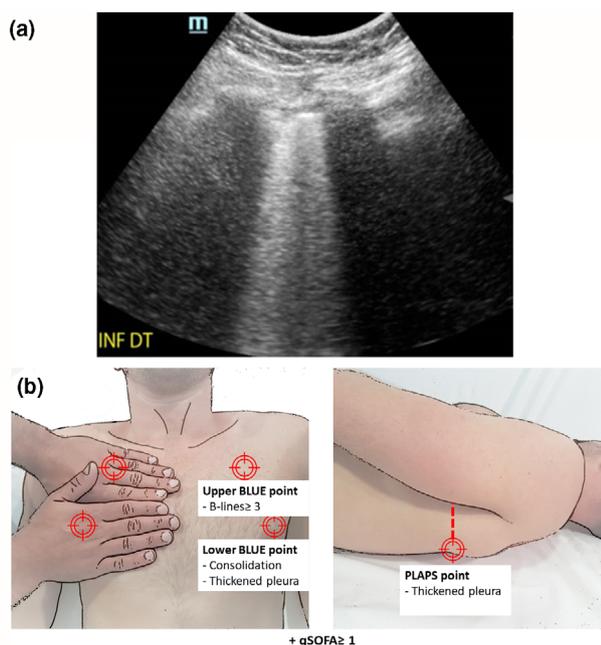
(a) Lower anterior chest subpleural consolidation associated with thickened pleura. (b) The 'bed-side lung ultrasound in emergency' (BLUE) protocol interrogates three points in each hemithorax. The two anterior sites are under one (upper) and two (lower) hands placed below each clavicle. The posterolateral site is the posterior transverse continuation from the lower anterior site, interrogated as posterior as possible in the supine patient
